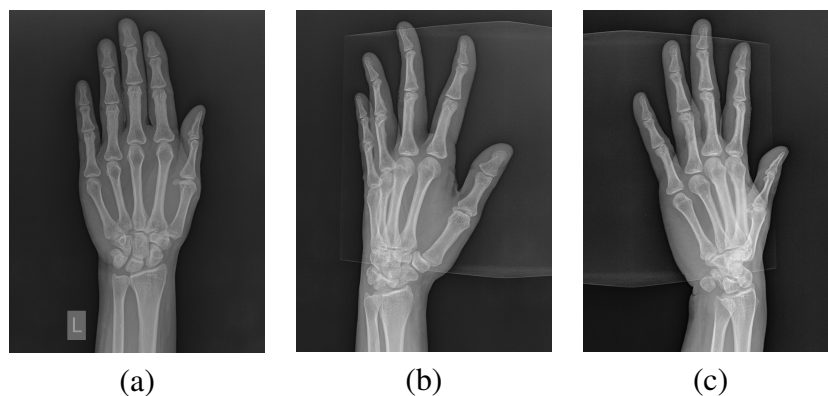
Multi-view radiographic images of the hand used for 3D reconstruction: (a) PA view, (b) 45° oblique view and (c) 135° oblique view
